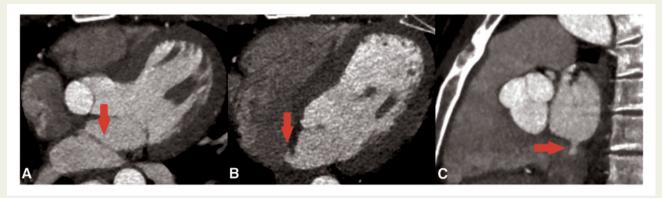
Cardiac computed tomography angiography. (A) The cor triatriatum sinister membrane (arrow). (B and C) Small atrial septal defect in axial and sagittal views (arrows).
